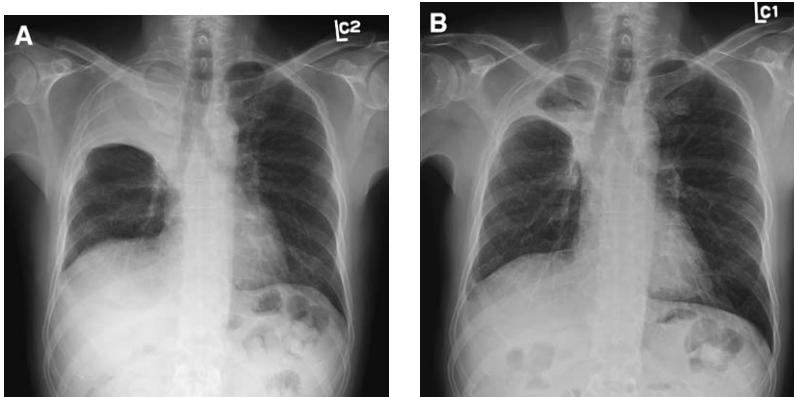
Bronchopleural fistula in a 57-year-old man who underwent right upper lobectomy for poorly differentiated non-small cell lung cancer. (A) Posteroanterior chest radiograph 3 months after surgery demonstrates diffuse opacification of the residual apical pleural space in the right hemithorax consistent with prior surgery. (B) Posteroanterior chest radiograph 9 months after surgery demonstrates the presence of a gas collection within the previously opacified pleural space, which was secondary to the development of a bronchopleural fistula. The fistula resolved after treatment incorporating pleural drainage.
